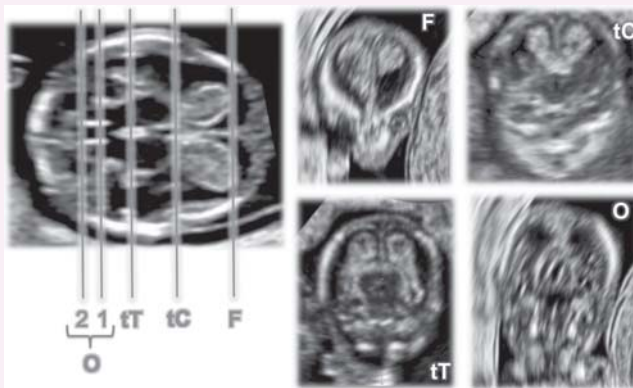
Coronal views of normal fetal brain on two-dimensional ultrasound imaging at 11–13 weeks: frontal (F), transcaudate (tC), transthalamic (tT) and occipital (O) planes.
